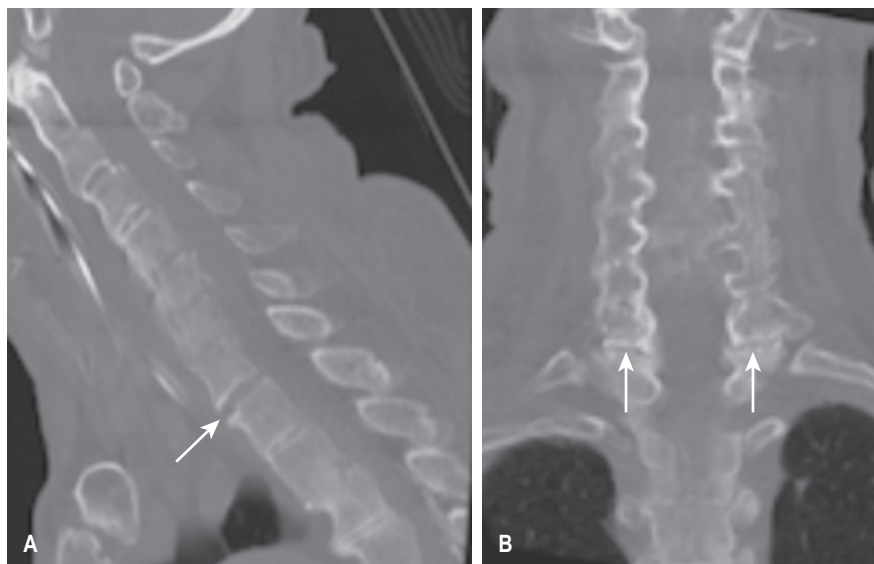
Fractures through a fused spine (long white arrows) in A (sagittal) and B (coronal) Computed Tomography views of the cervical spine are called ‘carrot stick’ fractures because they traverse the entire width of the vertebral column (like breaking a carrot). Note that ‘DISH’ refers to ‘diffuse idiopathic skeletal hyperostosis’.
